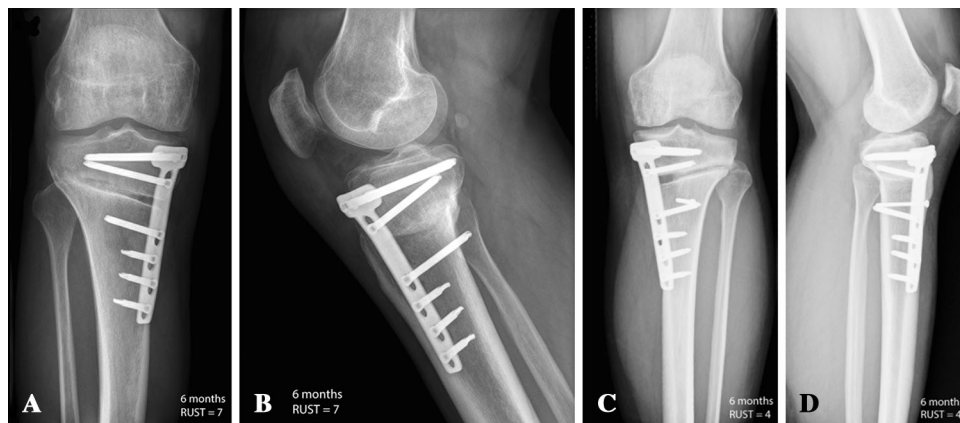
D (A) Normal union on AP radiograph 6 months postoperatively scored according to the modified RUST score. (B) Normal union on lateral radiograph 6 months postoperatively scored according to the modified RUST score. (C) Delayed/nonunion on AP
